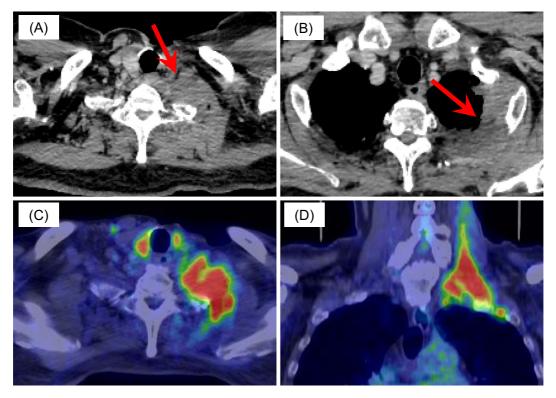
Chest CT and PET-CT findings. Chest CT showed (A) the swollen soft tissue in his left neck field and (B) thoracic wall thickening of the left apical portion. (C, D) PET-CT performed four months before admission showed the abnormal uptake of ¹⁸F-fluorodeoxyglucose (FDG) in his left neck field.
